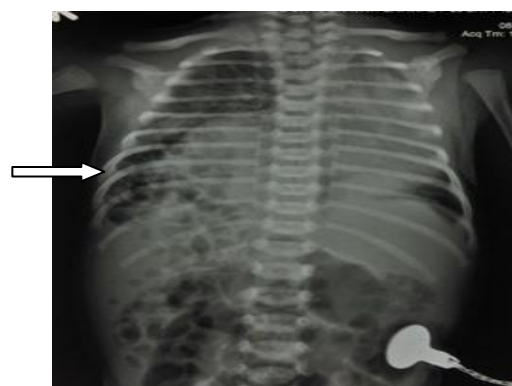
Conventional anteroposterior chest X-ray demonstrating air-filled loops of the bowel in the right hemithorax and a paucity of gas in the abdomen. The right diaphragm is not discernible and there is an extensive mediastinal shift to the left side.
